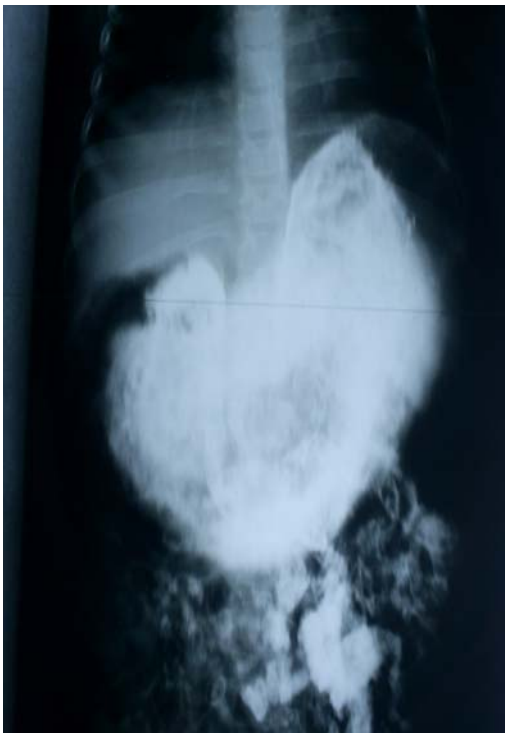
Barium meal radiography showing intragastric mass.
